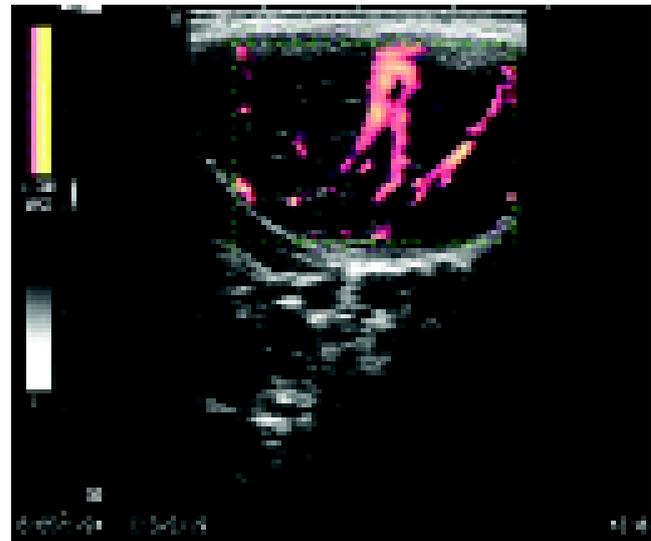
Power doppler image of enlarged left submandibular region lymphnode shows large feeding artery penetrating the nodal hilum and prominent vascular channels in the periphery and the center of the lesions.
